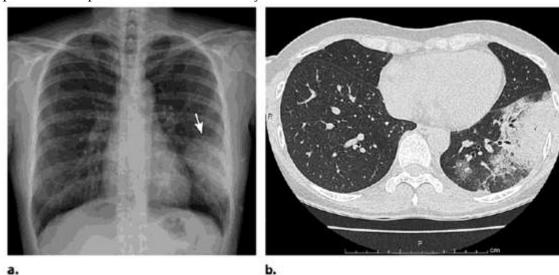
(a) PA chest radiograph shows sublobar consolidation in the left inferior lobe (arrow) with a round morphology. (Figure 4a is reprinted with permission from reference 100.) (b) Axial chest CT image (lung window) shows peripheral consolidation and ground-glass opacities typical of lobar pneumonia. No tree-in-bud micronodules or bronchial mucoid impaction are seen.
